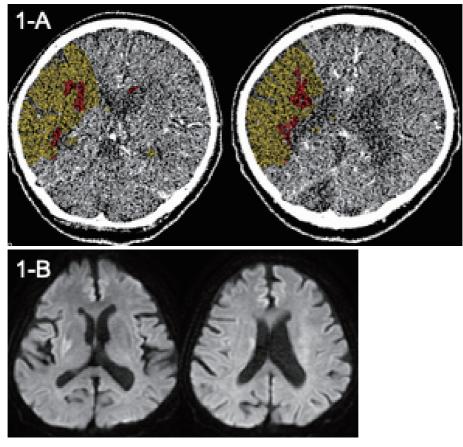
Overestimation of the infarct area by Vitrea software A: On a CT perfusion scan, there is an increase of 8 points (lens nucleus, insula, and corona radiata).
